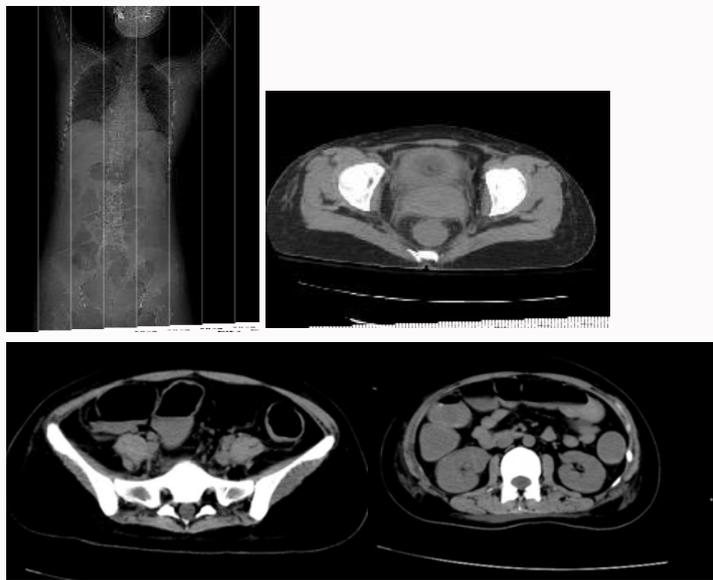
Abdominal computed tomogram.
